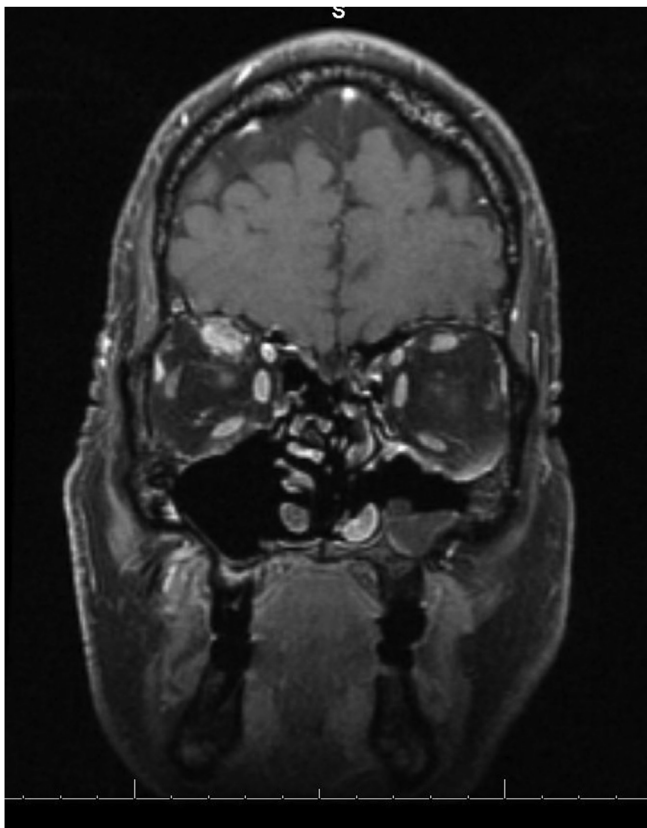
Magnetic resonance imaging of the orbit (3 mm), coronal view, T1 fat saturated, post gadolinium, demonstrating enlarged, homogenously enhancing right superior rectus muscle with irregular border.
